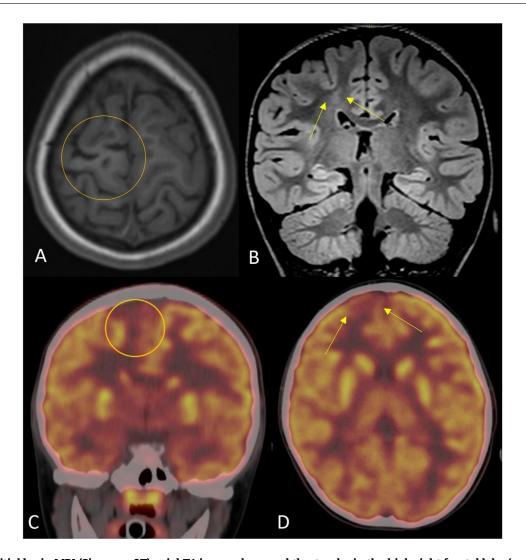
(A) Initial brain MRI (Siemens, 3T) axial T1 image shows subtle atrophy in the high right frontal lobe (superior frontal and precentral gyri- circle). (B) Coronal FLAIR image shows subtle T2 hyperintensity in the subcortical white matter deep to the cortical atrophy in the paramedian right frontal lobe (arrows). (C) FDG PET/CT coronal image shows corresponding hypometabolism in the paramedian right frontal lobe (circle). (D) PET/CT axial image shows additional patchy hypometabolism in the anterior right frontal lobe.
